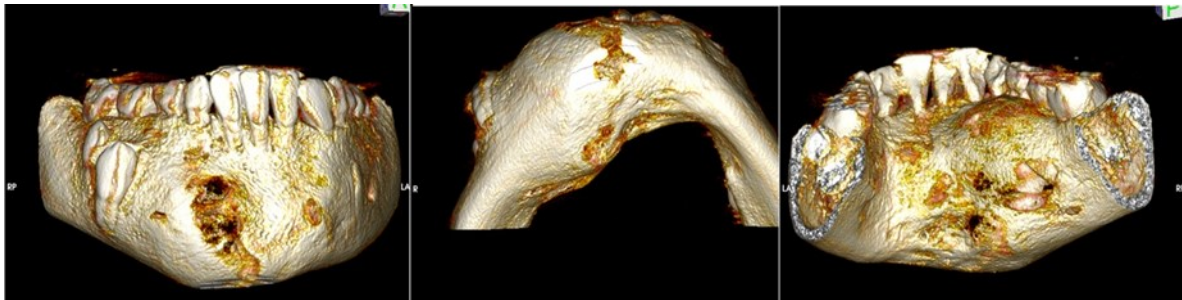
CBCT 3D reconstruction.
